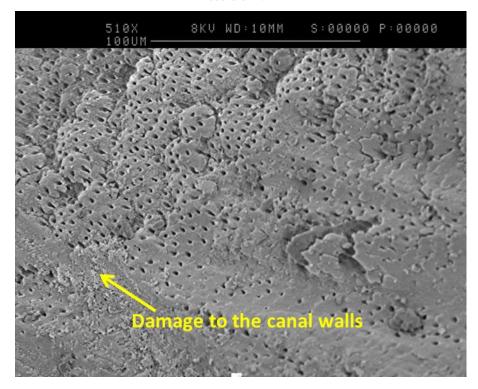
SEM image (500x magnification) of the root canal wall in the cervical third after dynamic continuous replenishment with 10% NaOCl at 25°C for 5 minutes (Group 9), with debris and predentine score of 4. Damage to the canal walls was noted, probably from contact with the ultrasonic file.
